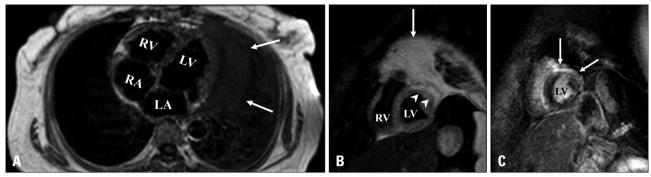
A: Axial T1-weighted imaging showing the mass inseparable from the left ventricular wall (arrows). B: Short-axis T2-weighted imaging showing myocardial edema in the anterior and lateral walls of the left ventricle (arrowheads) with high signal intensity of the mass (arrow). C: Short-axis late gadolinium enhancement imaging showing non-ischemic sub-epicardial to mid wall late enhancement involving the anterior wall with extension to a small portion of anterior septum/anterolateral walls (arrows). LA: left atrium, LV: left ventricle, RA: right atrium, RV: right ventricle.
